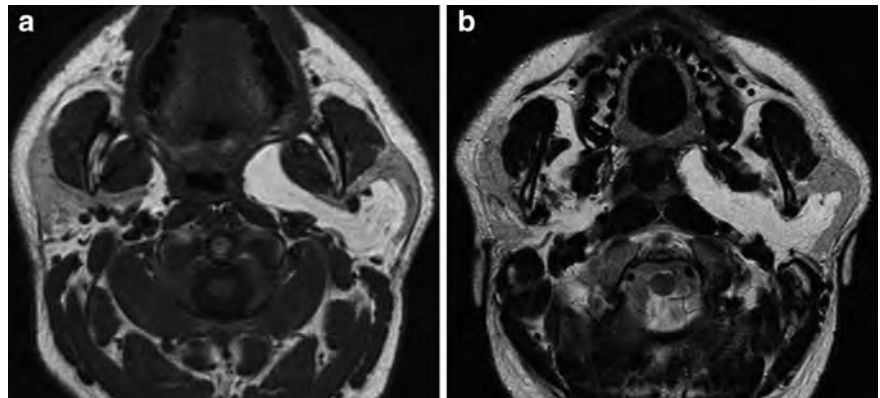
Lipoma of the left parotid gland extending to the deep lobe and the anterior parapharyngeal space, showing a spontaneous high T1-weighted (a) and a high T2-weighted signal intensity (b)
